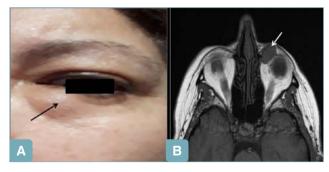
(A) Clinically, a nodular mass (arrow), firm in consistency is evident in the left orbital region; (B) MR imaging showing a solid mass with well circumscribed borders, exhibiting a mild hypointense T2 signal (arrow).
